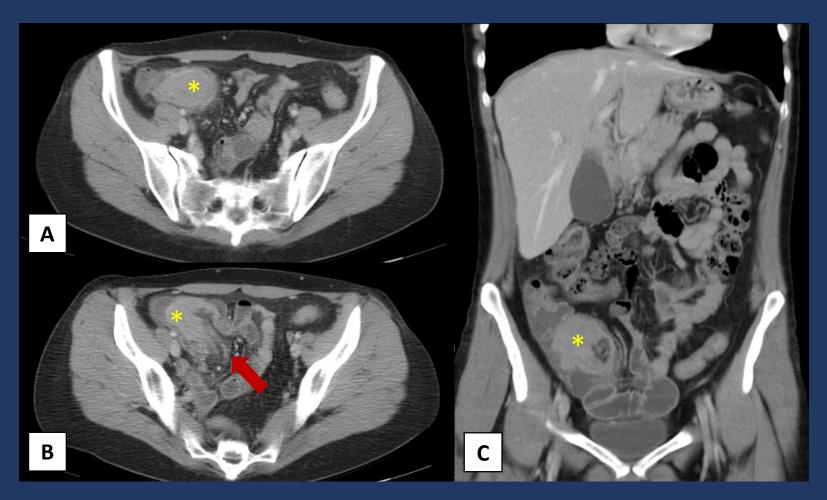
Axial (A, B) and coronal (C) contrast-enhanced CT shows ileocolic intussusception (arrow) caused by a large polyp (asterisk), that was found to be a lymphoma.
